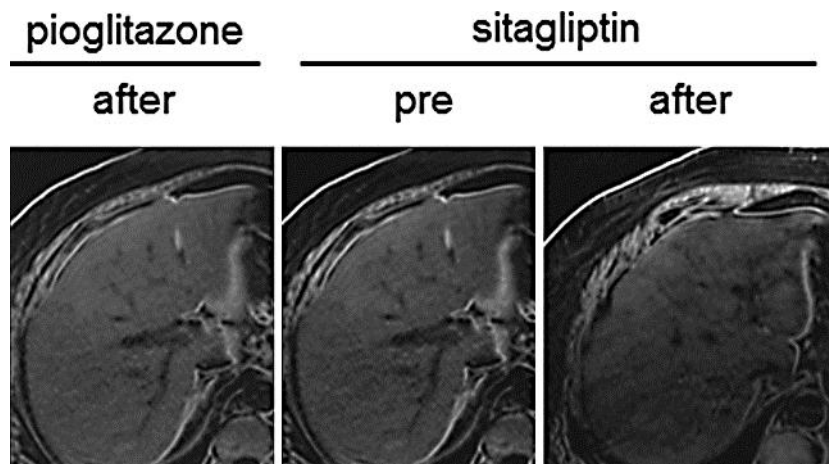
Changes in MRI imaging during the medical treatment. All images are T1 subtraction images.
